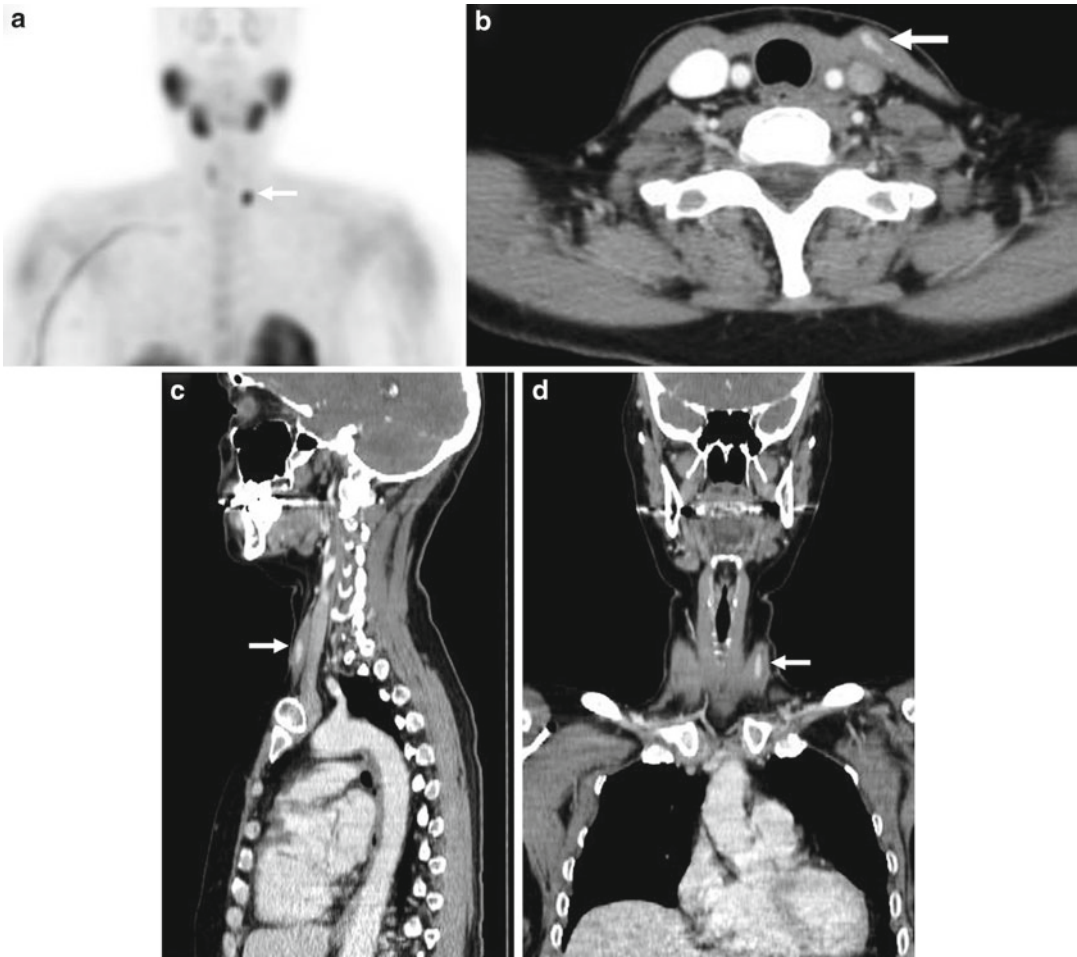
Parathyroid autotransplant in the left sternocleidomastoid muscle. Planar sestamibi scan (a) shows focal radiotracer activity in the left neck laterally (arrow). Contrast-enhanced CT in the transverse (b), sagittal
